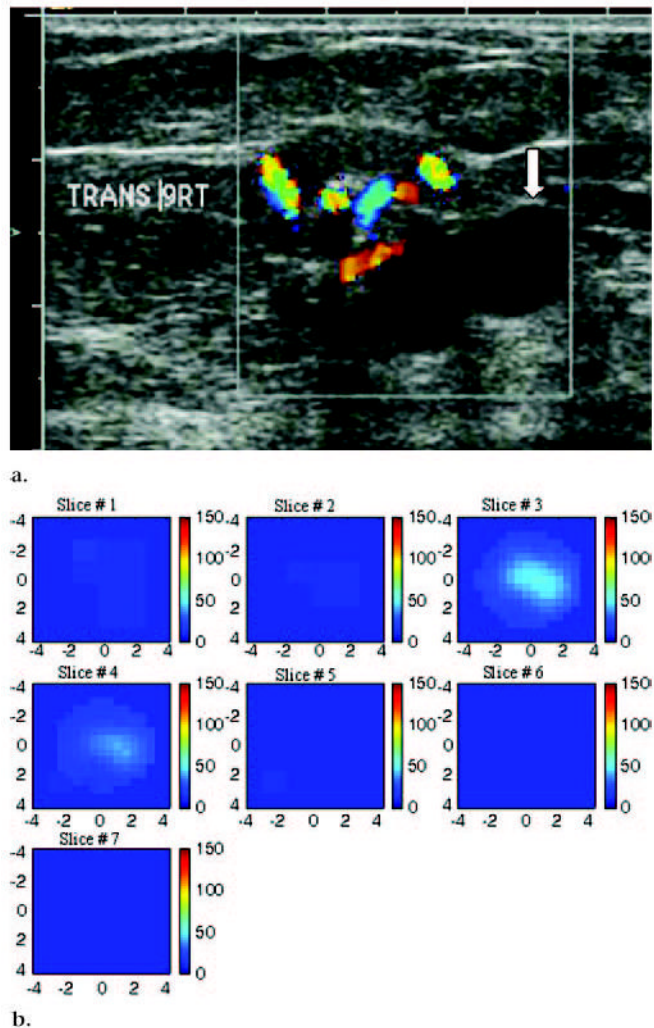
US image and hemoglobin concentration maps of infiltrating lobular carcinoma (nuclear grade 2–3) located at 12 o’clock position in right breast of 37-year-old woman. (a) US image demonstrates lesion (arrow) measuring 1 cm in diameter. No blood vessels or blood flow were seen at color Doppler US. (b) Total hemoglobin concentration map computed from absorption maps (not shown) obtained at 780 nm and 830 nm. Hemoglobin map reveals isolated high concentration mass in sections three (*slice #3*) and four (*slice #4*). Maximum hemoglobin concentration was 102.1  $\mu\text{mol/L}$ , and average hemoglobin concentration was 68.7  $\mu\text{mol/L}$ , as measured within FWHM region. Vertical scale presents total hemoglobin concentration in micromoles and ranges from 0 to 150  $\mu\text{mol/L}$ .
